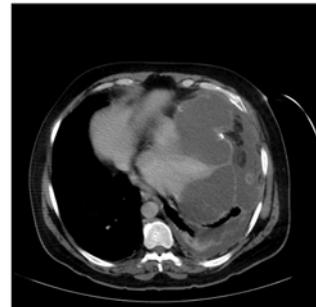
Dynamic Chest CT scan done in 2009.
